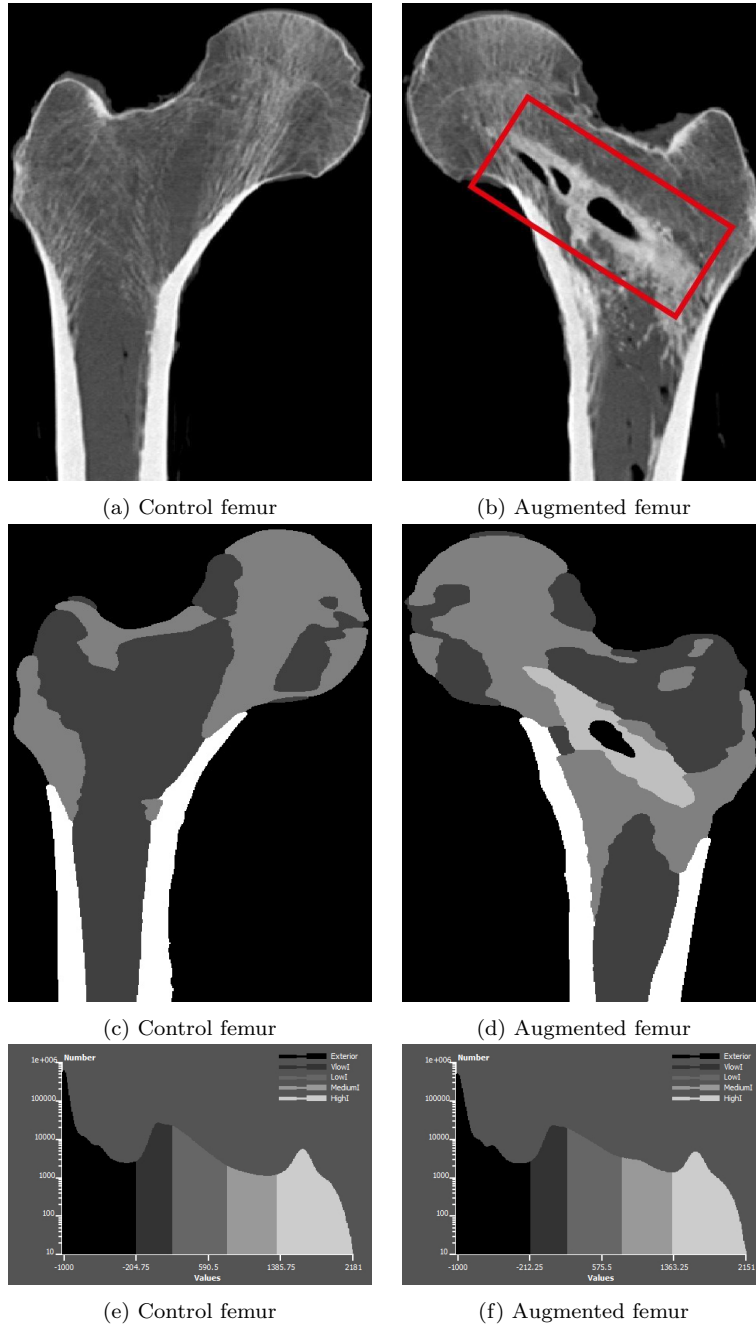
Anterior view of coronal radiographic slices (3a and 3b) and corresponding segmentation label (3c and 3d) of the selected pair of femurs. The cement implant is visible in the augmented femora (right). 3e and 3f show an intensity histograms of the image volumes of the selected pair of femora.
